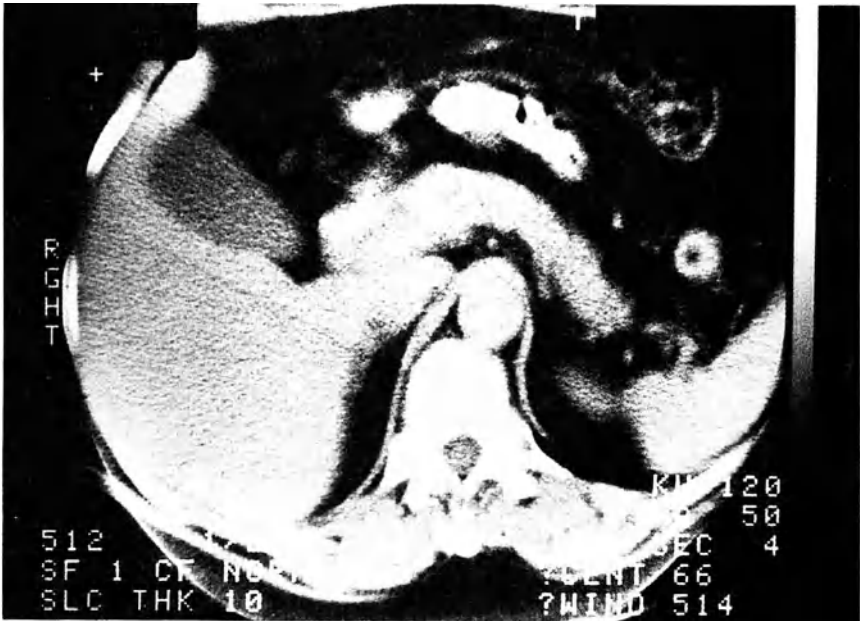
CT scan of the normal liver
